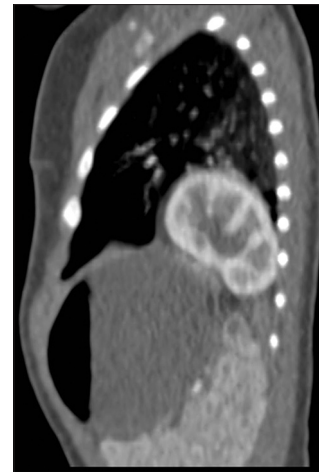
Sagittal reconstruction of computed tomography thorax demonstrates an intrathoracic kidney
